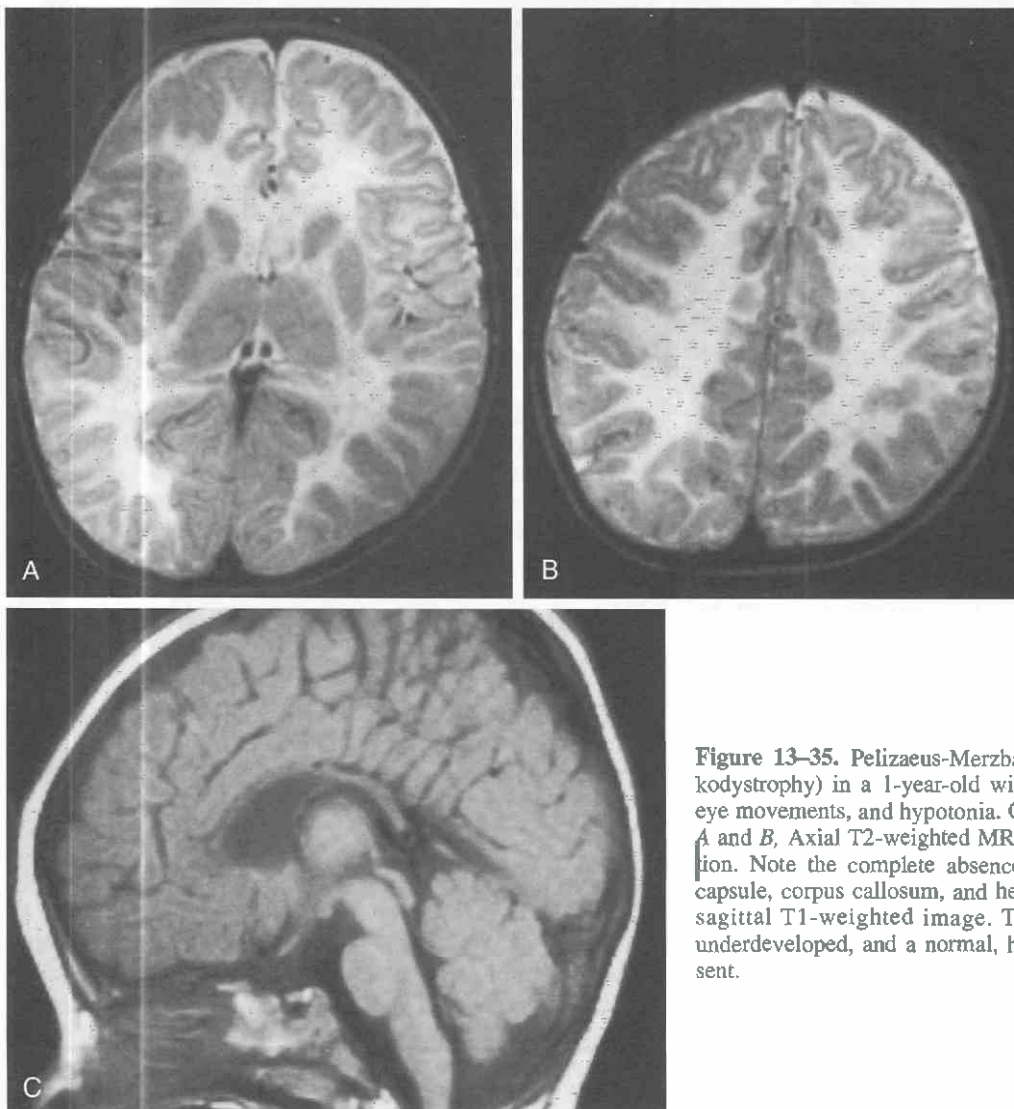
Pelizaeus-Merzbacher disease (sudanophilic leukodystrophy) in a 1-year-old with marked retardation, abnormal eye movements, and hypotonia. Cranial MR images at age 1 year. *A* and *B*, Axial T2-weighted MR images. Profound hypomyelination. Note the complete absence of myelination in the internal capsule, corpus callosum, and hemispheric white matter. *C*, Mid-sagittal T1-weighted image. The corpus callosum is notably underdeveloped, and a normal, hyperintense myelin signal is absent.
